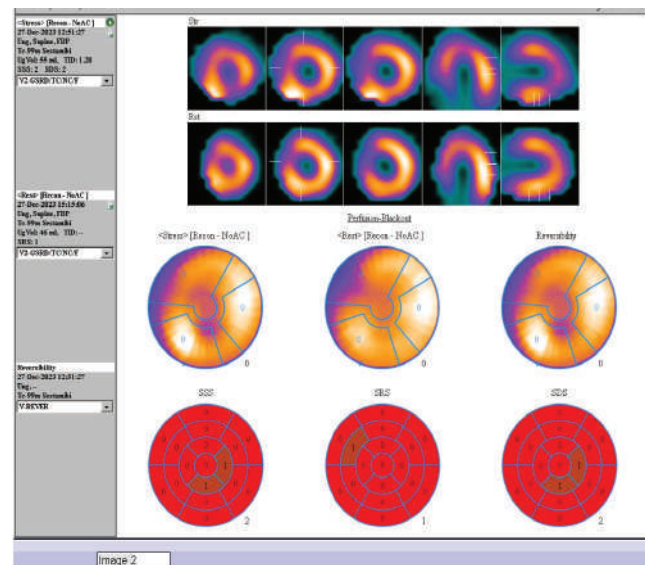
17 segment ^{99m}Tc - sestamibi gated SPECT Myocardial perfusion scan image showing normal perfusion at all segments but high transient ischemic dilation (1: 20)
